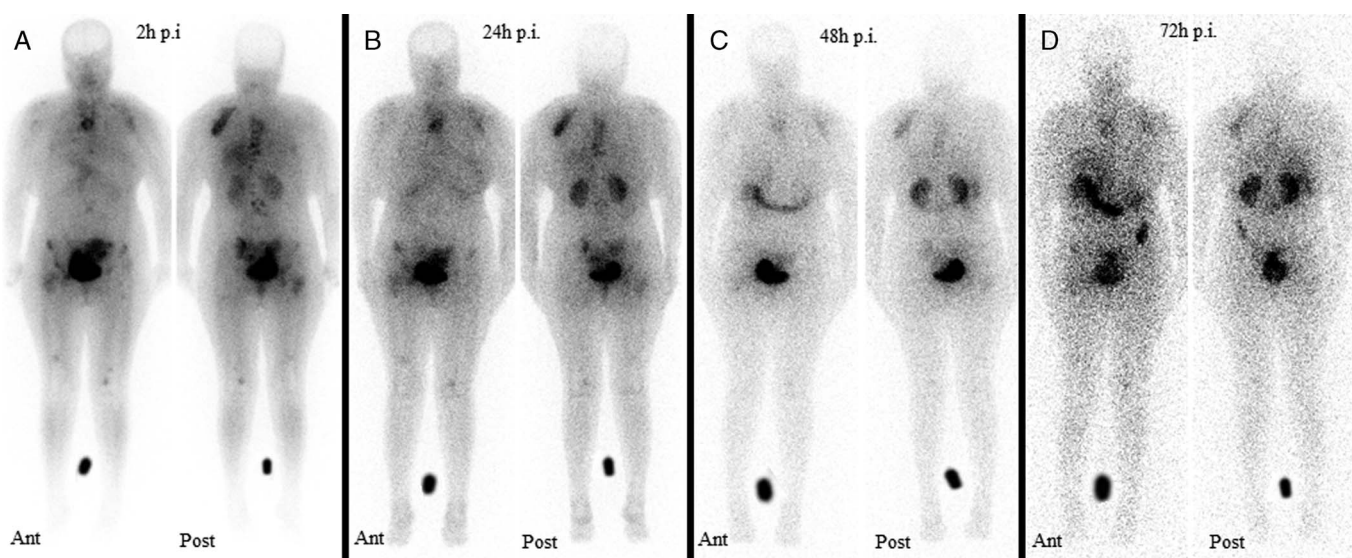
Planar scintigraphy (anterior and posterior views) after therapeutic application of ¹⁷⁷Lu-FAPI-46 at 2 hours (before voiding) (A), 24 hours (B), 48 hours (C), and 72 hours (D) postinjection in a 52-year-old patient with breast cancer. The images revealed several FAP-avid lesions throughout the body and tumor retention of ¹⁷⁷Lu-FAPI-46 in the lesions.
